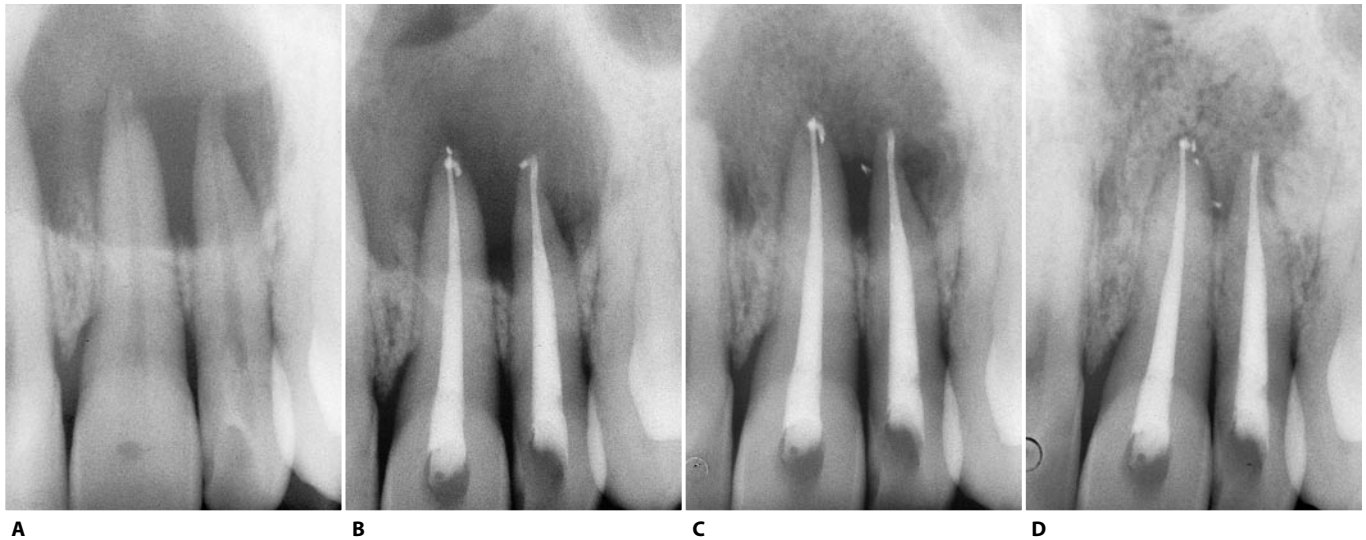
A. Preoperative radiograph of the upper left central and lateral incisors. The two teeth do not respond to the tests of pulp vitality. The radiographic appearance of the large lesion which surrounds the two apices suggests a cyst. B. Postoperative radiograph. C. Six months later. D. Two years later.
